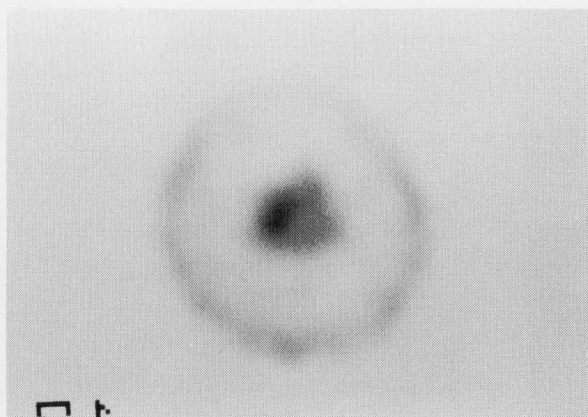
Technetium-99m HMPAO SPECT image (axial). Increased accumulation in the intraventricular tumor was visible compared to normal brain cortex.
